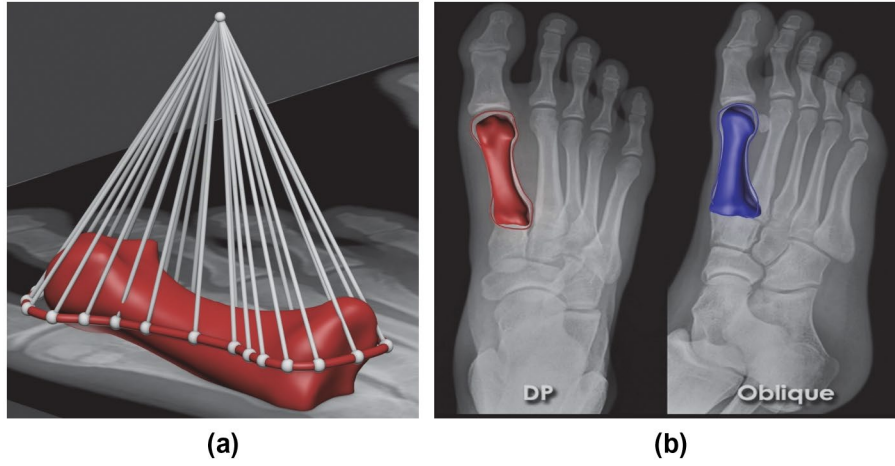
(a) Calibration procedure of the bone with the contour silhouette on the X-ray. (b) Calibration of the bone on the left and right contour.
